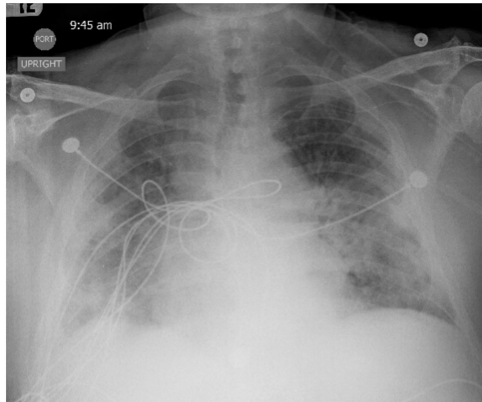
Chest X-ray on day 1 depicting diffuse bilateral pulmonary opacities.
